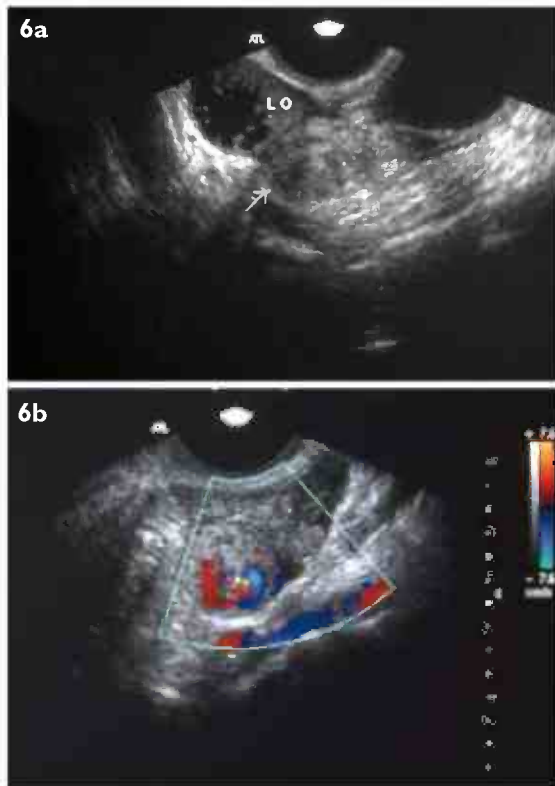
(a) Grey-scale TVUS image shows a torsional right adnexa (arrow) containing a hypoechoic "whirl" of vessels. (b) This is well-demonstrated with colour Doppler TVUS imaging as the "whirlpool sign". A small amount of adnexal fluid is also present.
